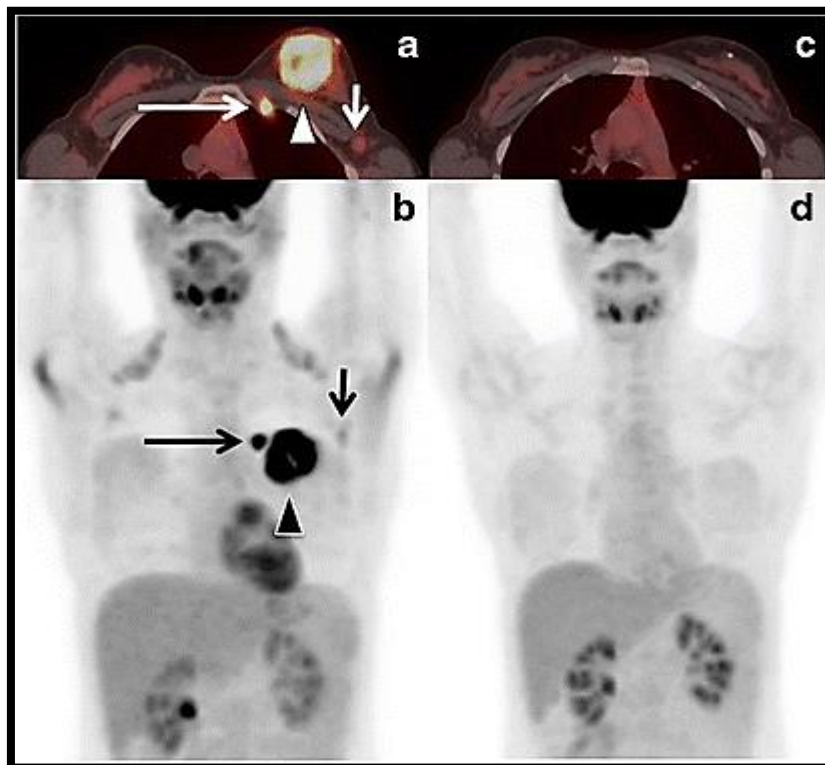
A 38-year-old breast cancer patient with internal mammary nodal metastasis detected by PET/CT that was verified by imaging follow-up. A breast cancer patient with internal mammary nodal metastasis detected by PET/CT that was verified by imaging follow-up. a. PET/CT and b. PET images showed the primary breast cancer (arrowheads), axillary node (short arrows), and previously unknown left internal mammary node (long arrows). c. PET/CT and d. PET images following 5 months of neoadjuvant chemotherapy showed resolution of all FDG avid lesions (23).
